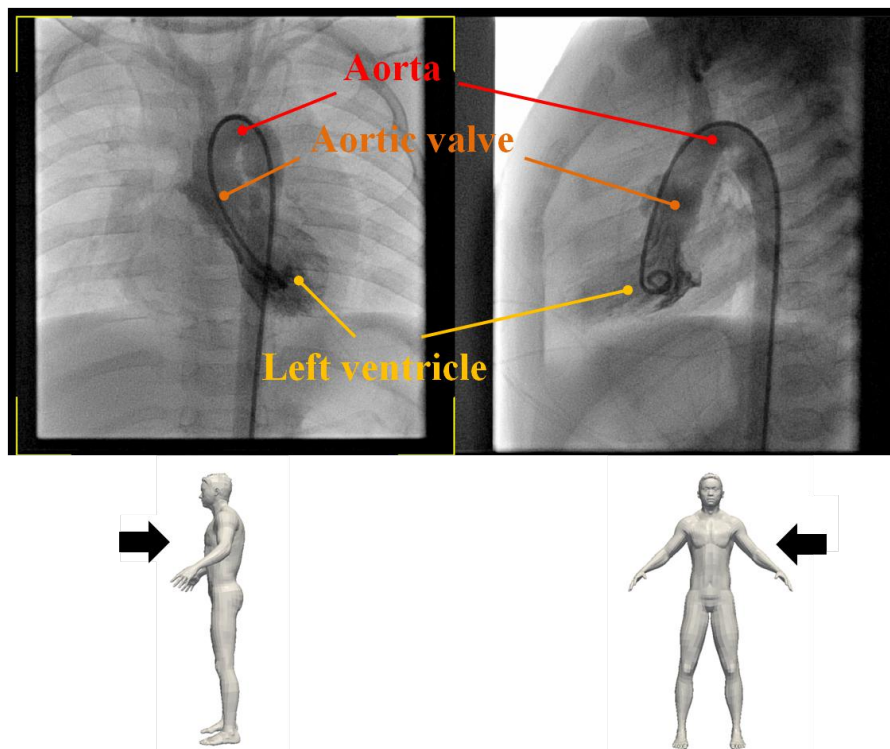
CT images of left ventricle and aorta (left: front view, right; side view)
